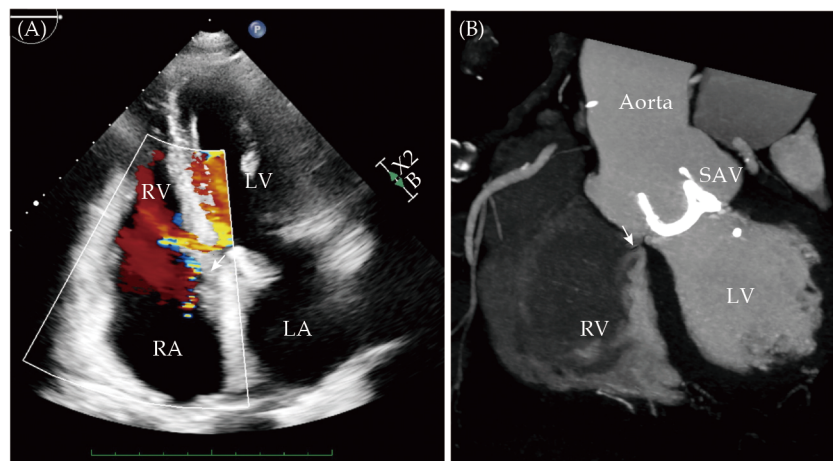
Echocardiographic and computed tomography pre-planning. (A) Echocardiographic four chamber view with color Doppler flow (white arrow) across the septum into the RV; and (B) computed tomography coronal view showing the location of the fistula (white arrow) in relationship to the adjacent structures. LA: left atrium; LV: left ventricle; RA: right atrium; RV: right ventricle; SAV: surgical aortic valve.
